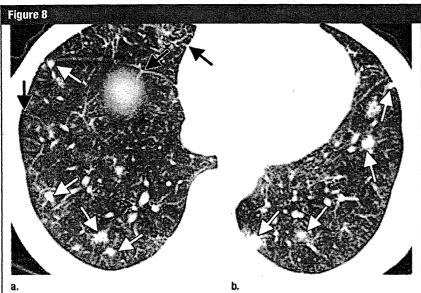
(a, b) Thin-section CT scans in a 59-year-old woman (case 11) with IgG4-related lung disease reveal multiple small nodules in both lungs (white arrows). These nodules distribute in the centrilobular areas. Mild interlobular septal thickening is also identified (black arrows).
